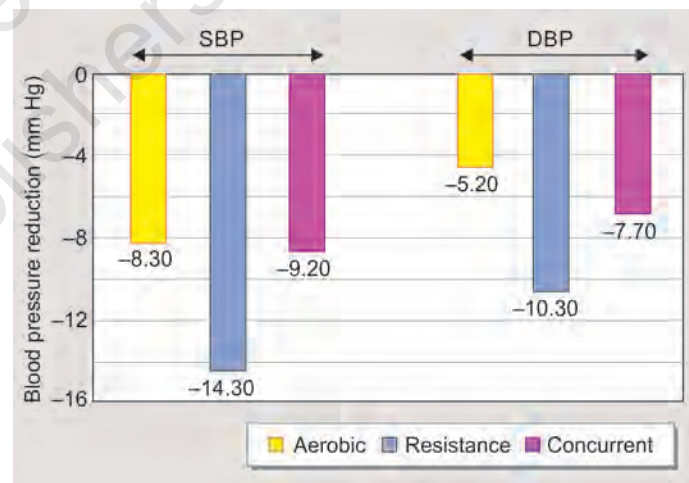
Blood pressure reduction following aerobic, resistance and concurrent training (CT) in hypertension (HTN) patients.
